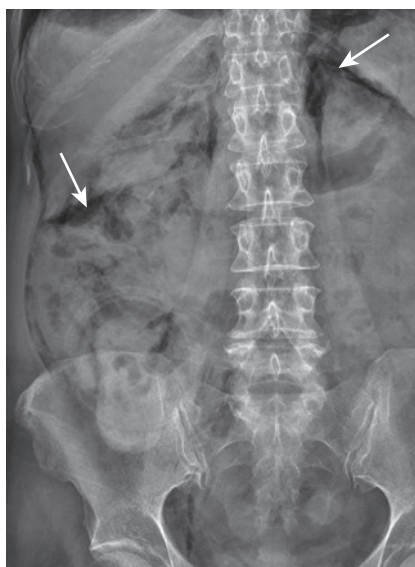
Plain radiograph of the abdomen demonstrating retroperitoneal gas following injury to the duodenum (*long arrows*).
